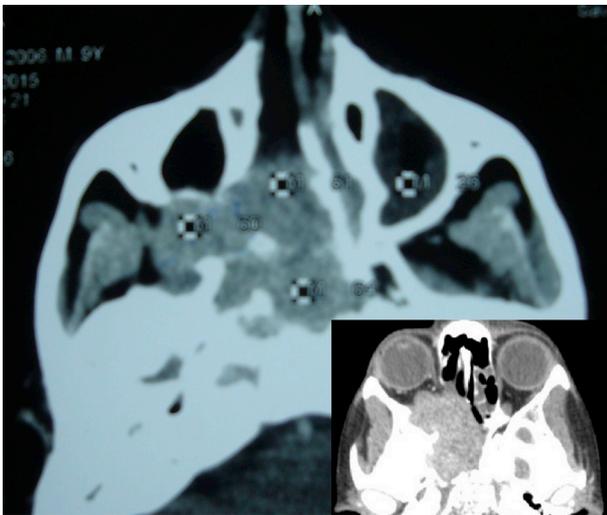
CT Scan (axial cut) showing widened sphenopalatine foramen, complete involvement of sphenopalatine fossa and the tumour extending laterally into the infratemporal fossa through pterygomaxillary fissure. The cancellous bone of basiphoid including base of pterygoid is also eroded. The inset CT Scan (contrast enhanced, axial cut) showing a large recurrence on the right side involving the nasal cavity, posterior ethmoids, sphenoid sinus, orbit and basiphoid including pterygoid base on the right side.
